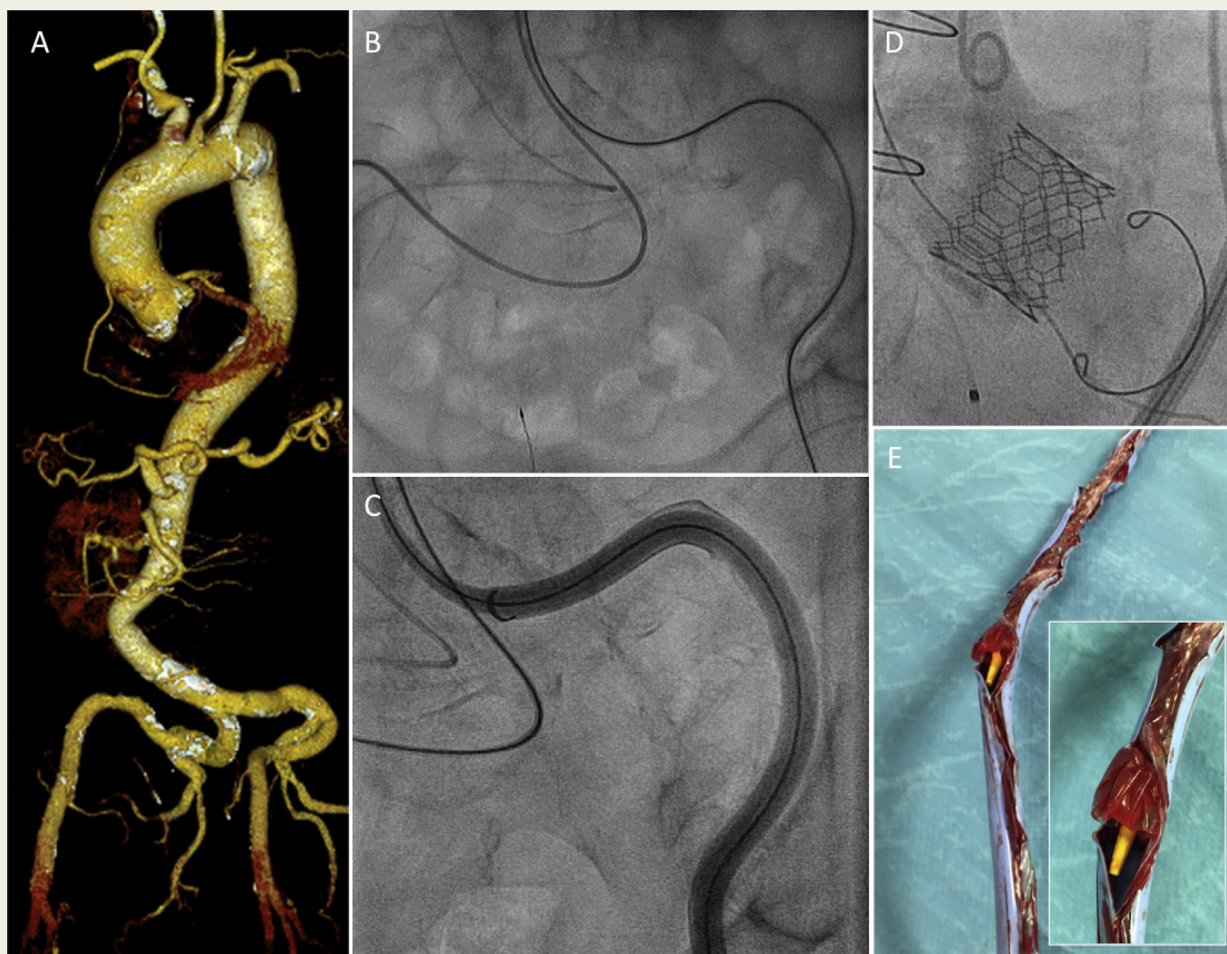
Case 1: Panel A – 3D MDCT reconstruction of the aorta and iliofemoral vessels demonstrating severely tortuous iliac arteries; Panel B – Frontal plane angiographic image showing severe persistent iliac tortuosity despite placement of bilateral stiff 0.035'' guidewires; Panel C – Frontal plane angiographic image during placement of a left-sided 16F vascular sheath with visible sheath malformation due to tortuosity; Panel D – Annular plane angiographic image during contrast aortography demonstrating appropriate deployment of the aortic prosthesis; Panel E – Marked disruption of the access sheath after removal with the dislocated portion of the balloon lodged within the sheath (inset). MDCT = Multi-detector computed tomography
